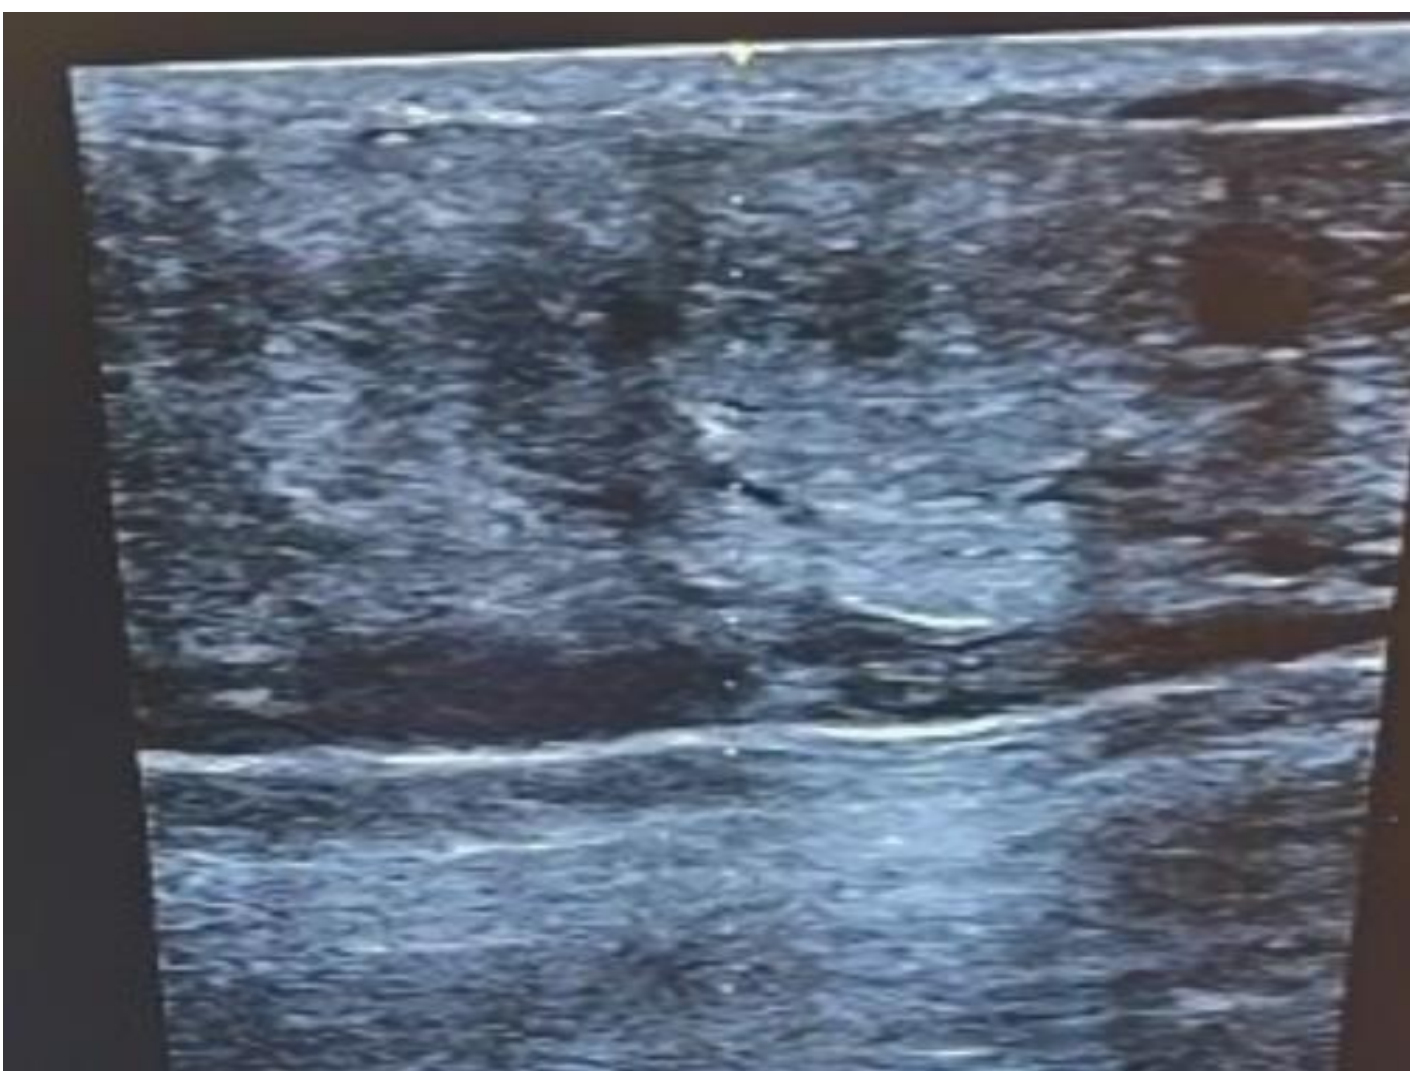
Location of ultrasound probe, Figure 6: Ultrasound image
